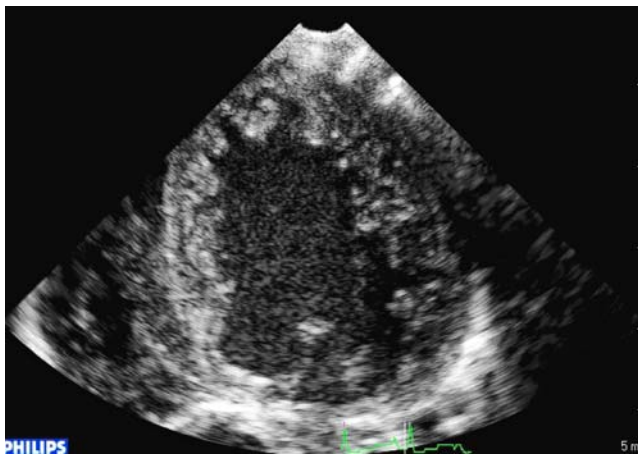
Echocardiography of this patient showed the typical manifestation of left ventricular noncompaction with the feature of hypertrophic left ventricle with numerous prominent trabeculations and deep intertrabecular recesses
